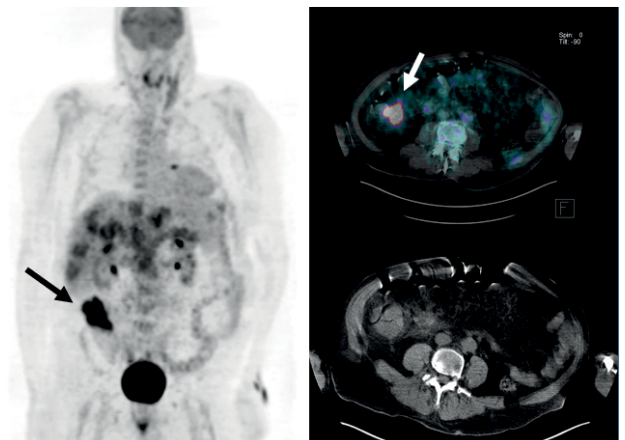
FDG-PET/CT showing hypermetabolic alterations compatible with cecum/ascending colon tumor (arrows) extending to adjacent adipose planes.
